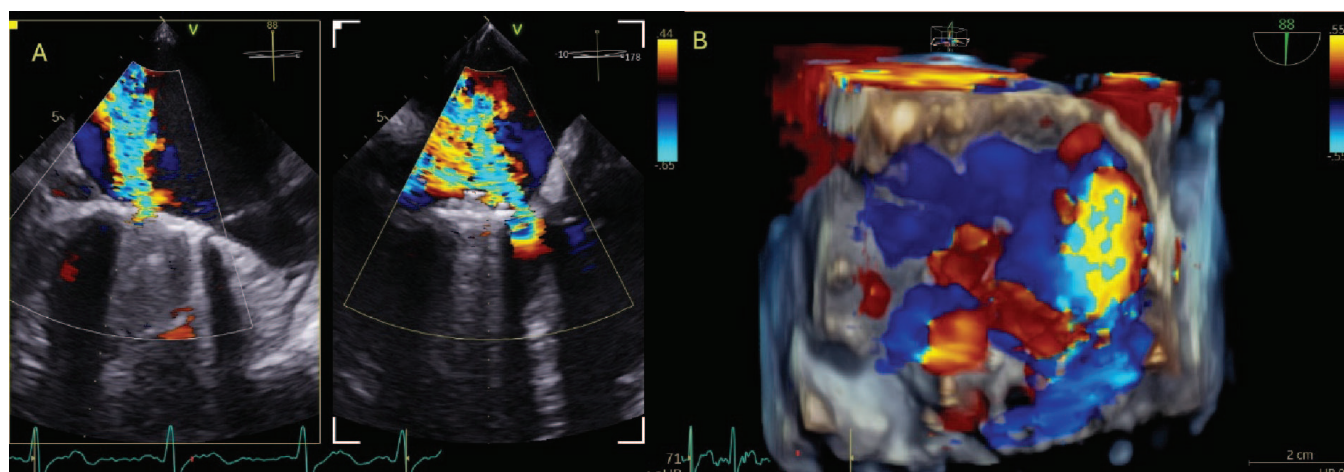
Preprocedural transesophageal echocardiography showing a paravalvular leak originating in the anteromedial region.
